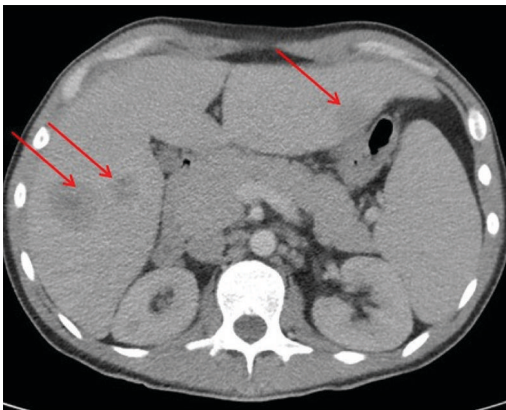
CT of liver showing multiple round low attenuation lesions.
